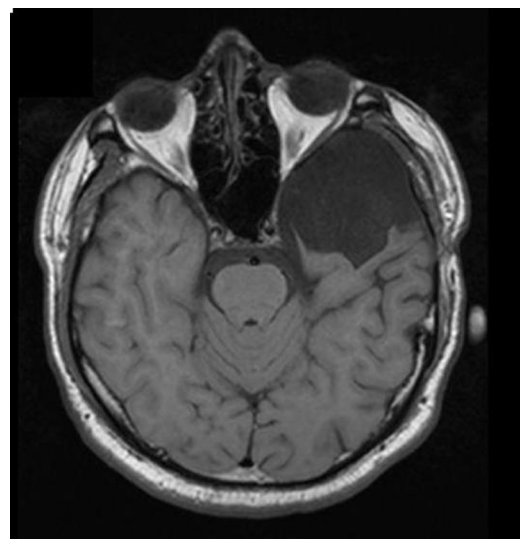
MRI scan, T1 weighted image. A arachnoid cyst (Galassi 2) is seen in the left Sylvian fissure.
